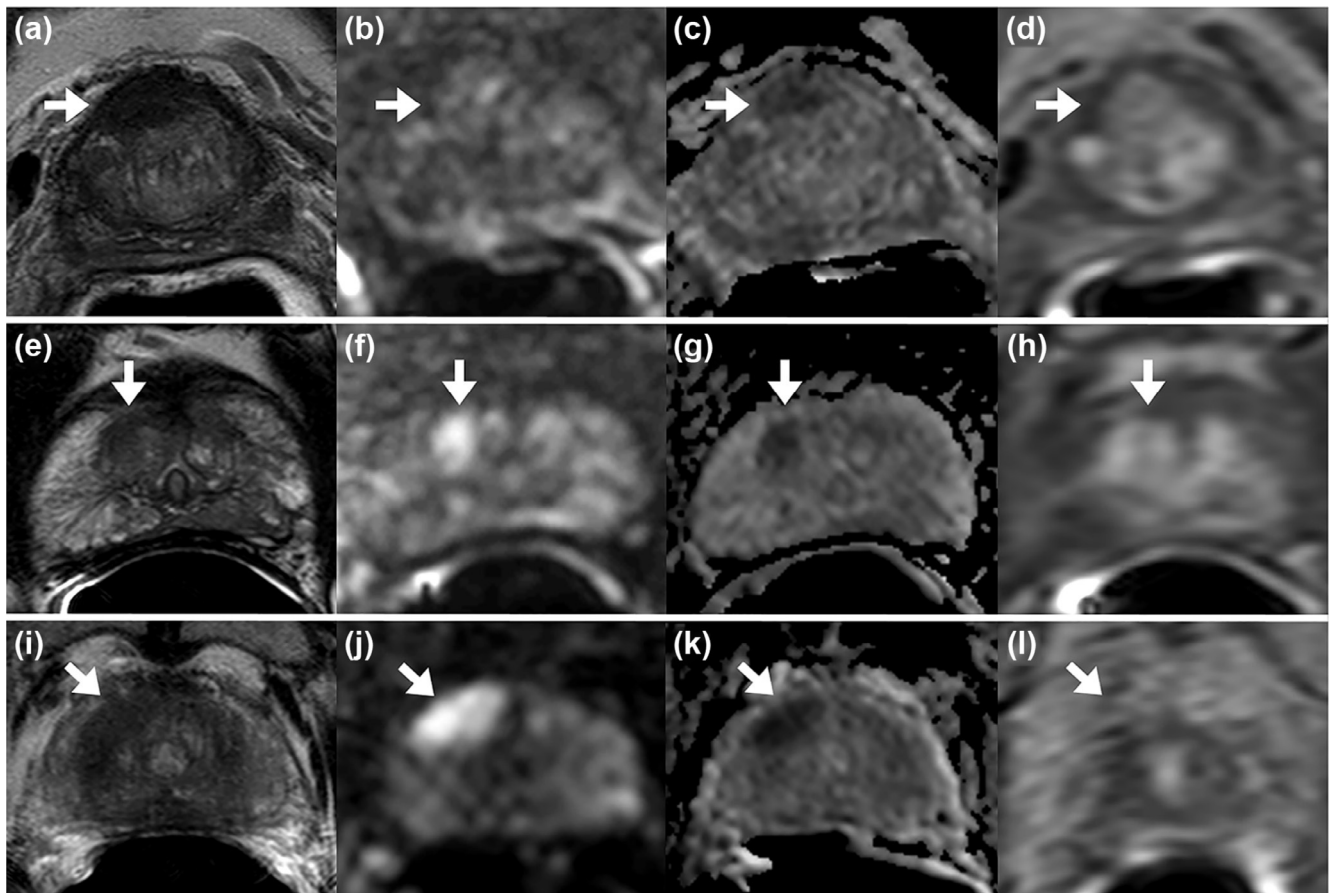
Panels (a–d): example T2-weighted (T2W)-only detection. A 58-year-old man with a serum prostate-specific antigen (PSA) of 7.09 ng/mL. All readers identified a lesion on axial T2W magnetic resonance imaging (MRI) that shows a hypointense lesion in the right anterior transition zone (arrow, a). Only one of three readers identified this lesion on diffusion imaging, including apparent diffusion coefficient (ADC) map (b) and b -2000 diffusion-weighted imaging (DWI, c). None of the readers detected this lesion on DCE (dynamic contrast-enhanced) MRI (d). The patient underwent radical prostatectomy and subsequent pathology mapping revealed Gleason 3 + 4 within this lesion. Panels (e–h): example DWI-only detection. A 51-year-old man with a serum PSA of 4.47 ng/mL. None of the readers reported findings on T2W MRI in this patient (e). All readers detected a lesion in the right apical anterior transition zone with restricted diffusion on ADC (f) and b -2000 (g) DWI. None of the readers detected this lesion on DCE MRI (h). The patient underwent radical prostatectomy and subsequent pathology mapping revealed Gleason 3 + 4 within this lesion. Panels (i–l): example T2W+/DWI+ detection. A 66-year-old man with serum PSA of 8.9 ng/mL. All readers reported a lesion on axial T2W MRI (i) in the right mid anterior transition zone. All readers additionally reported this lesion (arrows) on DWI, including ADC map (j) and b -2000 DWI (k). None of the readers detected this lesion on DCE MRI alone (l). Pathology mapping after radical prostatectomy revealed Gleason 3 + 4 within this lesion.
